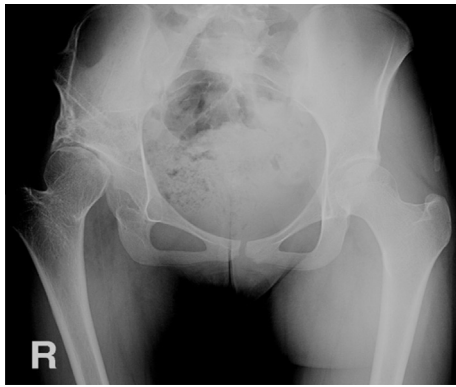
Anteroposterior radiograph at the final follow up showing full head coverage and center-edge angle of 40°.
